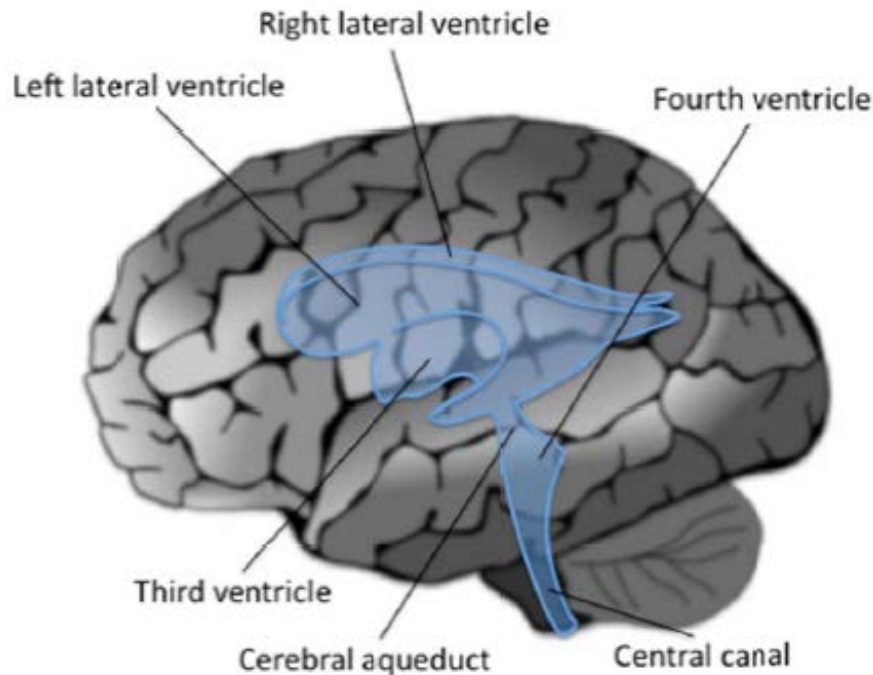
Shown is the ventricular system of the brain. The ventricles offer prominent anatomical landmarks when browsing through three-dimensional brain volumes obtained using, for example, magnetic resonance imaging. The ventricles are located deeper inside the brain and are here projected to the cortical surface for visualization purposes.
